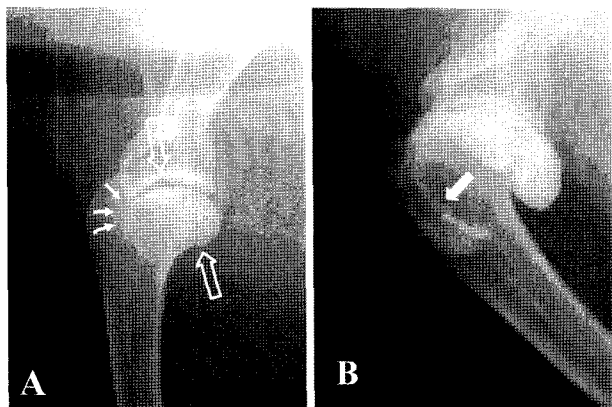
A, Radiograph of shoulder with biceps tenosynovitis in a Borzoi. Note the dense region of sclerosis in the bicipital groove (arrow) and periarticular changes (open arrow). This represents mineralization in the tendon or osteophyte production around the bursa. B, Arthrography of same region showed thickening and irregularity of bursa (arrow).
